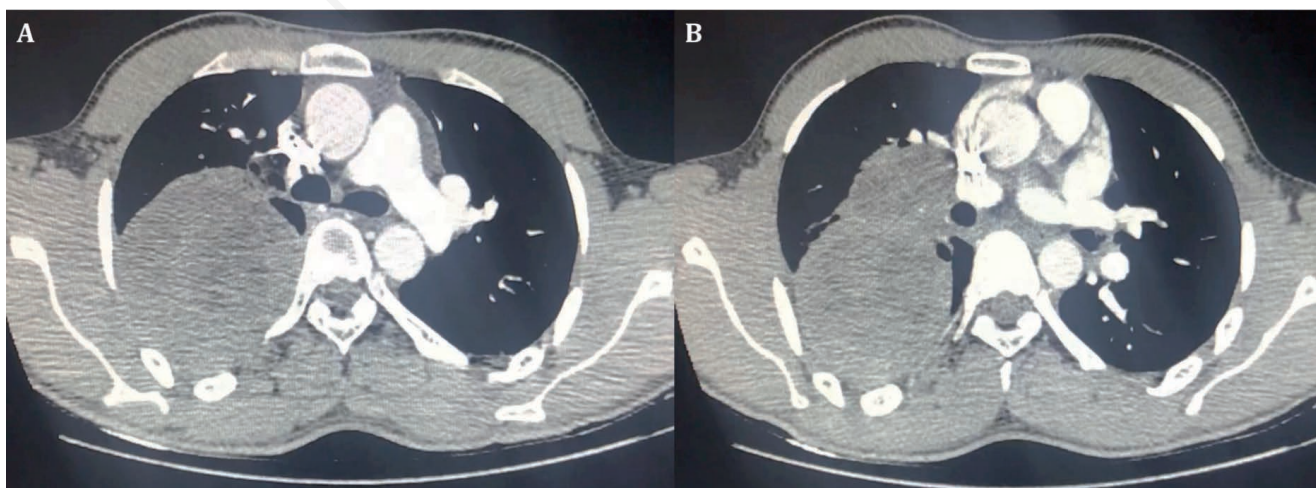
Chest CT images showing a right upper lobe soft tissue lesion with few areas of hypoattenuation.
